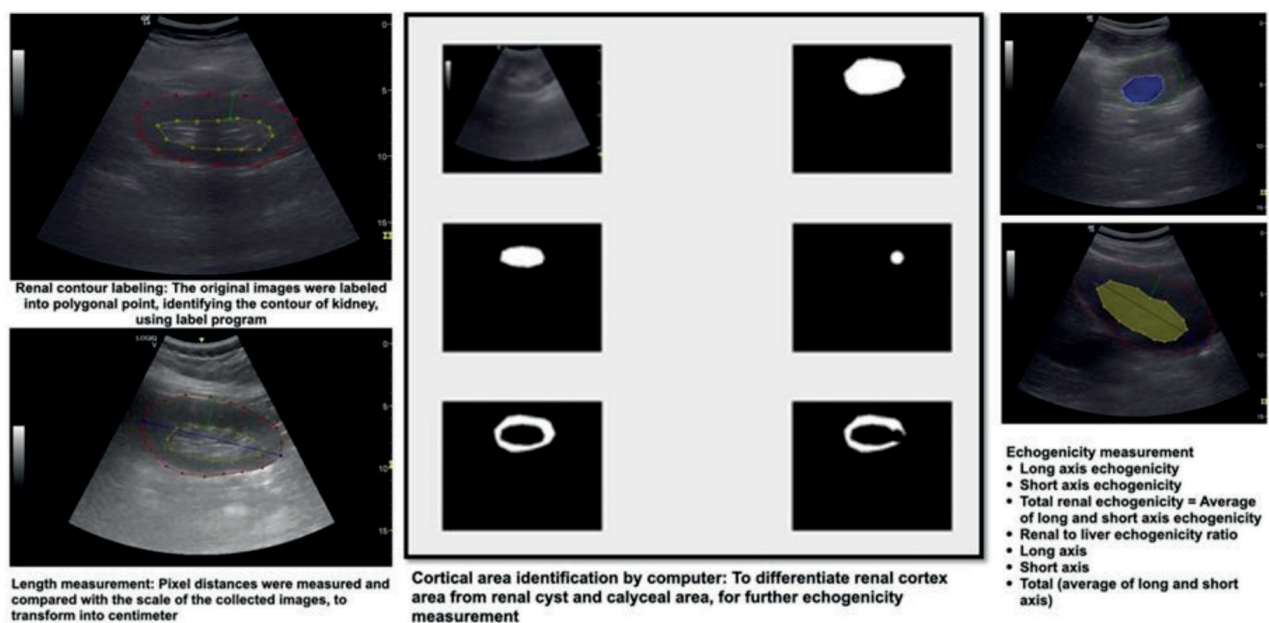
Analysis of sonographic images
